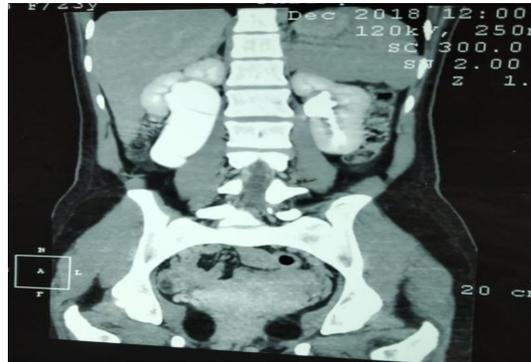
CT urography showing the dilated right renal pelvis and upper ureter
